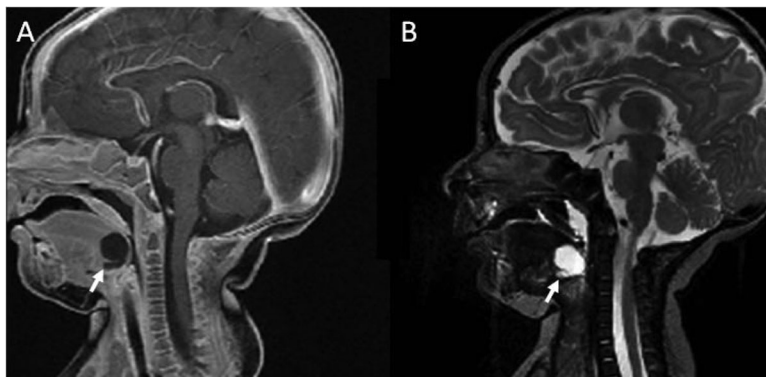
Sagittal contrast-enhanced T1-weighted (A) and sagittal fat-suppressed T2-weighted (B) MR images of a child with a suprahyoid thyroglossal duct cyst. The images reveal a well-defined, thin-walled cystic structure in the typical midline location at the level of the foramen cecum at the tongue base. No cyst wall enhancement is encountered on postcontrast imaging. Differentiation between a thyroglossal duct cyst located at the tongue base and a vallecular cyst is not possible based on imaging appearance alone.
